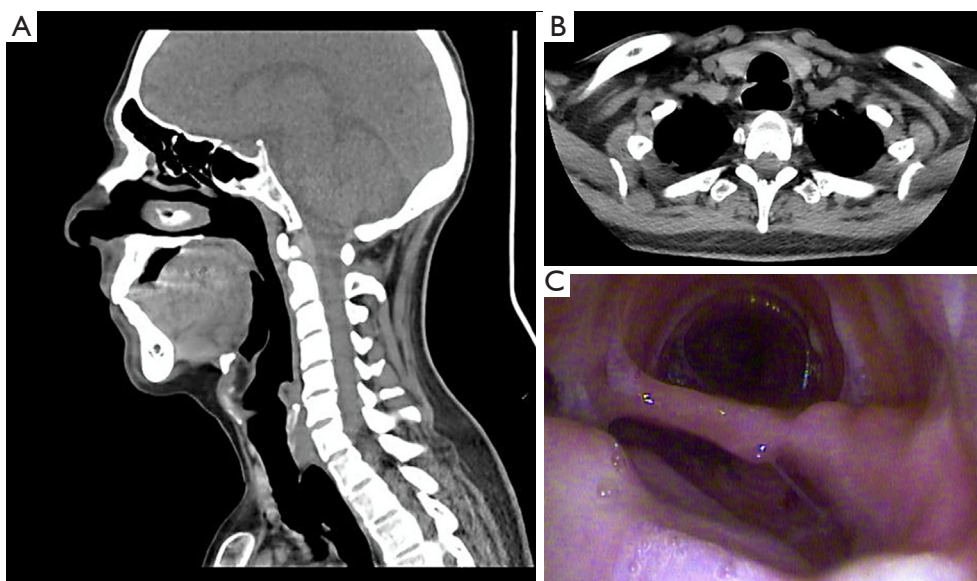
Tracheo-esophageal fistula showed by thoracic CT-scan and fiberoptic bronchoscopy. (A) Sagittal thoracic CT-scan showing tracheo-esophageal fistula; (B) axial thoracic CT-scan showing tracheo-esophageal fistula; (C) fiberoptic bronchoscopy showing tracheo-esophageal fistula.
